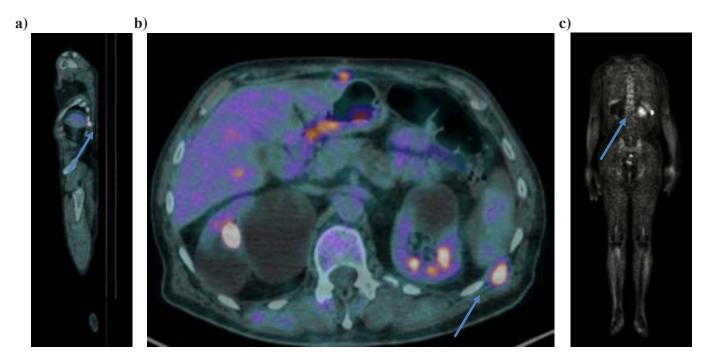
showing at the Xth intercostal space on the left hypercaptation of the metabolic tracer in the context of the intercostal muscle (SUV max 8.7), compatible with a metastatic lesion.
